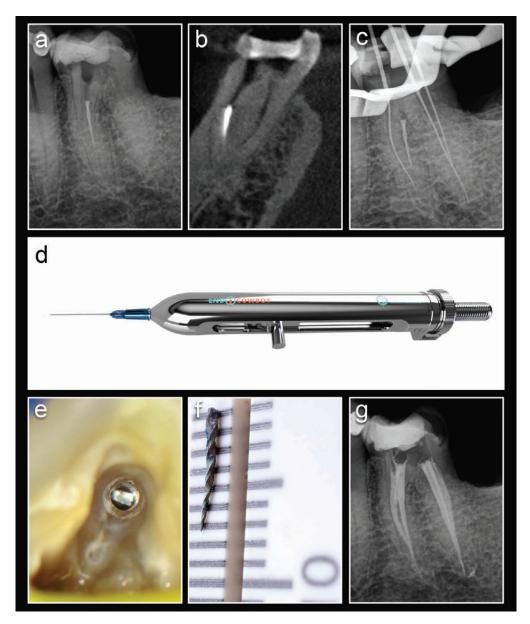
(a) Peri-apical radiograph showing a fractured instrument in the midroot area of the mesio-buccal root canal of a mandibular left first molar; (b) Sagittal view of a CBCT confirmed that the fragment was located at the point of maximum curvature of the root canal system; (c) Length determination peri-apical radiograph confirming that the mesio-lingual and mesio- and disto-buccal root canal systems were patent and could be negotiated to full working length; (d) EndoCowboy (Köhrer Medical Engineering), preloaded with the standard 0.12mm wire in a 0.5mm cannula; (e) Coronal aspect of the fractured fragment in the mesio-buccal root canal system under 12X magnification; (f) Extracted fractured fragment measuring 6mm on a ruler; (g) Postoperative peri-apical radiograph after root canal preparation and obturation of all the root canal systems
